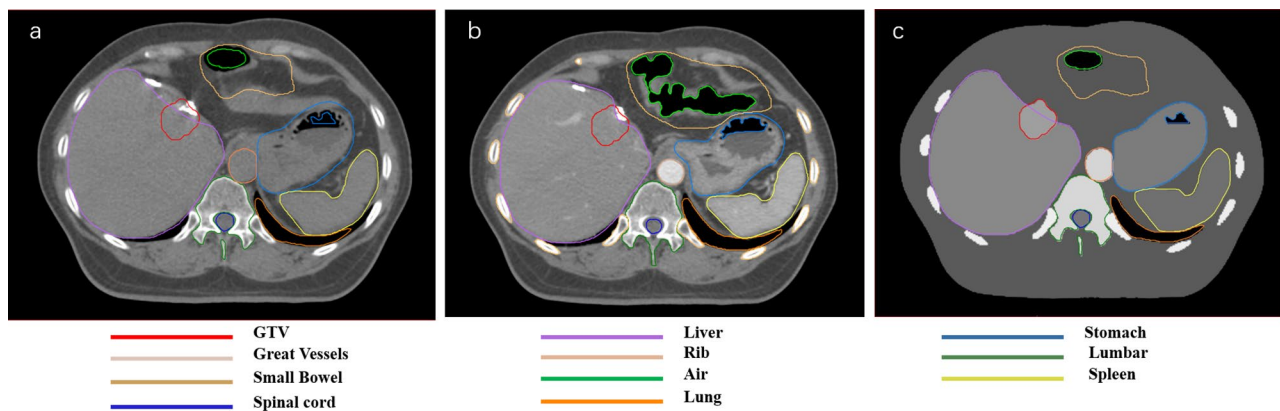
Synthetic CT (c) obtained from the plain CT (a) and contrast-enhanced CT (b) in transversal images for a representative patient
